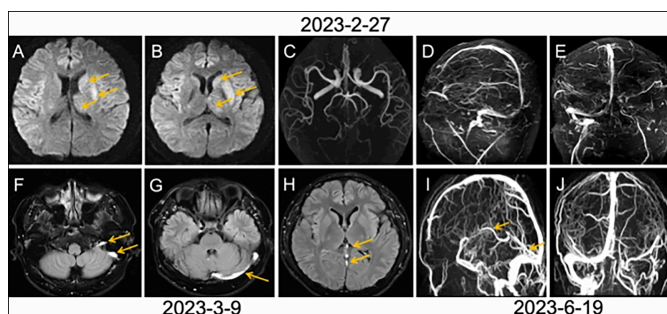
Brain magnetic resonance imaging findings. (A-E) Brain MR findings on 27 Feb 2023. (A, B) DWI indicates a high signal in the left caudate nucleus, lentiform nucleus, and thalamus (orange arrows). (C) Brain MRA shows no significant abnormality. (D, E) Brain MRV showed the occlusion of the inferior sagittal sinus, straight sinus, left transverse sinus, sigmoid sinus, and jugular venous bulb. (F-H) Brain MR findings on 9 Mar 2023. T2 FLAIR shows the thrombus in the straight sinus, left transverse sinus, sigmoid sinus, and jugular venous bulb (orange arrows). (I, J) Brain MR findings on 19 Jun 2023. Brain MRV shows recanalisation of the vein of Galen, internal cerebral veins, and straight sinus (orange arrows), as well as partial visualisation of the left transverse sinus, sigmoid sinus, and jugular venous bulb.
